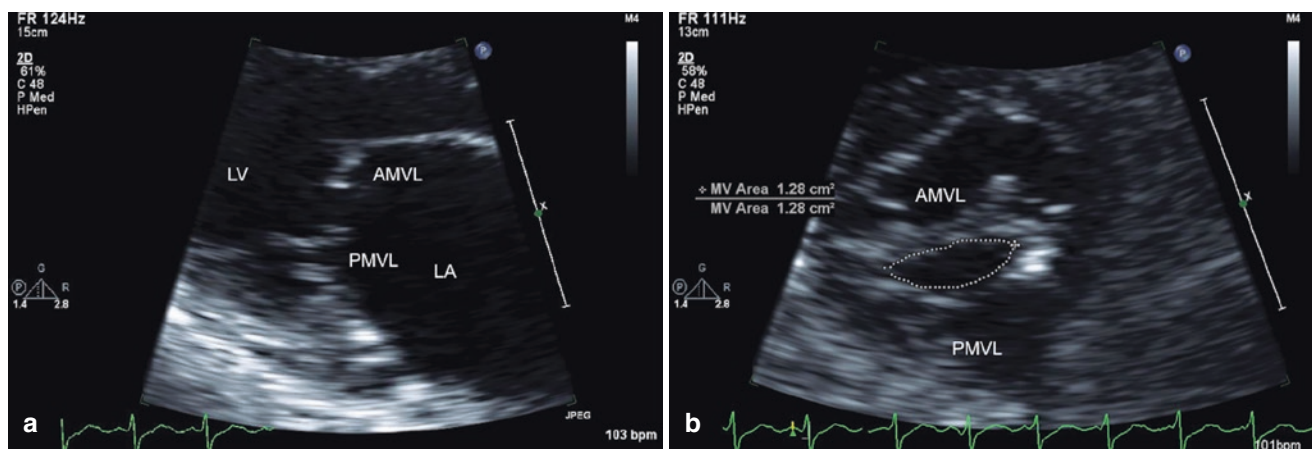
Severe rheumatic mitral stenosis. Rheumatic mitral valve disease is characterized by fusion of the mitral commissures as well as thickening of the mitral leaflets and/or subvalvular apparatus. Panel A shows a parasternal long-axis view of a rheumatic mitral valve. Fusion of the mitral commissures results in restriction of the leaflet tips with the basal and midportions of the leaflets moving more normally. This bowing in the mid-leaflet results in a characteristic “hockey stick”
